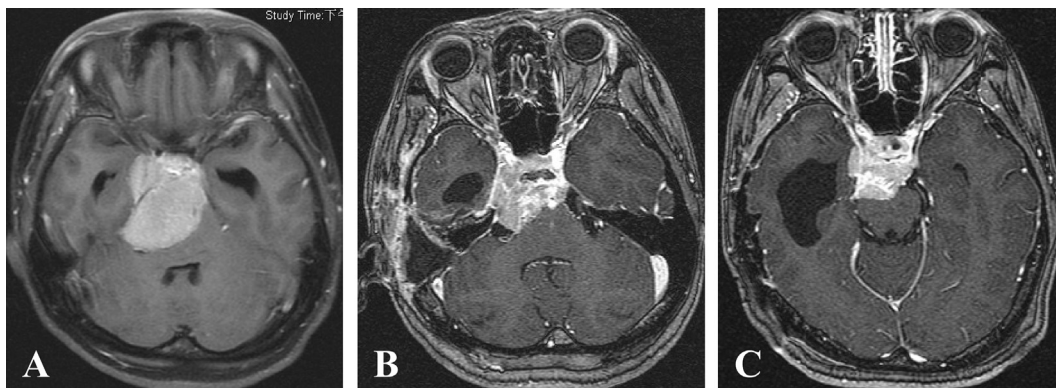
Case 3. (A) Pre-operative and (B) post-operative contrast-enhanced axial MR images, showing meningioma invading the cavernous sinus and compressing the brain stem. Axial MR images reveal (B) the reduction in tumor volume following surgical decompression (C) and tumor shrinkage following 2 stages of GKS treatment after a 96-month follow-up period.
